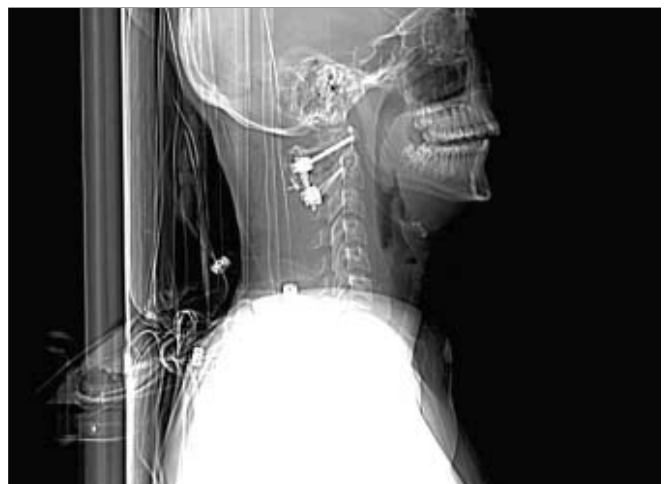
Lateral X-ray of a C1 lateral mass screw and C2 pars screw construct demonstrating the angulation and ideal positioning of the screws. An interspinous wiring has also been added to enhance the fusion
